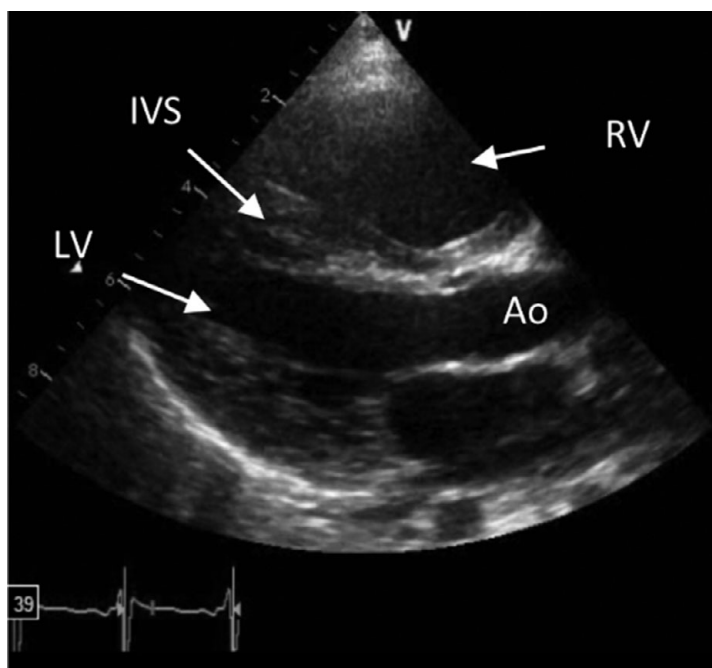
Parasternal long axis view of patient with severe pulmonary hypertension demonstrating a large right ventricle (RV), and bowing of the interventricular septum (IVS) into the left ventricle (LV) during systole. Ao, aorta. Courtesy of Adam C. Adler, MD
